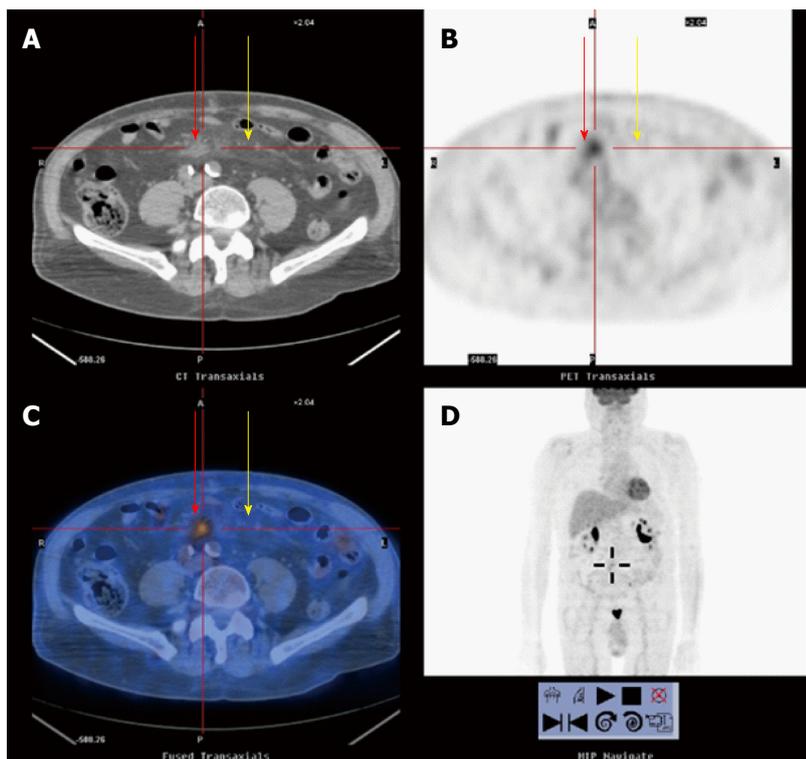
Mesenteric panniculitis in a patient with non-Hodgkin lymphoma. Positron emission tomography-computed tomography (PET-CT) scan following chemotherapy (same patient as Figures 3, 4 and 7). Computed tomography (CT) image (A), PET image (B), fused PET-CT image (C), and whole body PET image (D) demonstrates almost complete resolution of the mesenteric adenopathy (red arrow) with no fludeoxyglucose uptake in the portion of mesentery involved by mesenteric panniculitis (yellow arrows). The disseminated adenopathy seen in Figure 5D has almost completely resolved.
